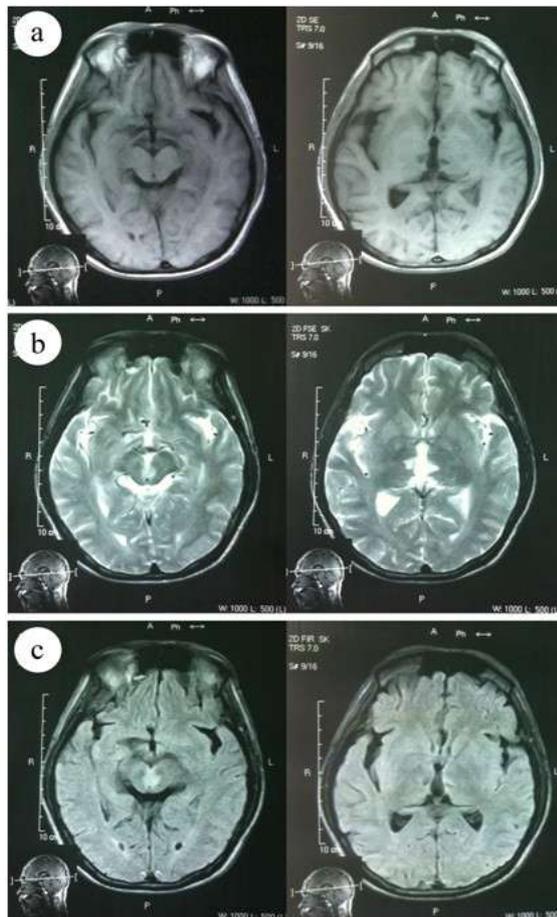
The MRI demonstrating symmetrical areas of low signal intensity on T1-weighted images bilaterally in midbrain and paramedian thalami (a), symmetrical areas of high signal intensity on T2-weighted (b), and FLAIR (c) images bilaterally in midbrain and paramedian thalami
